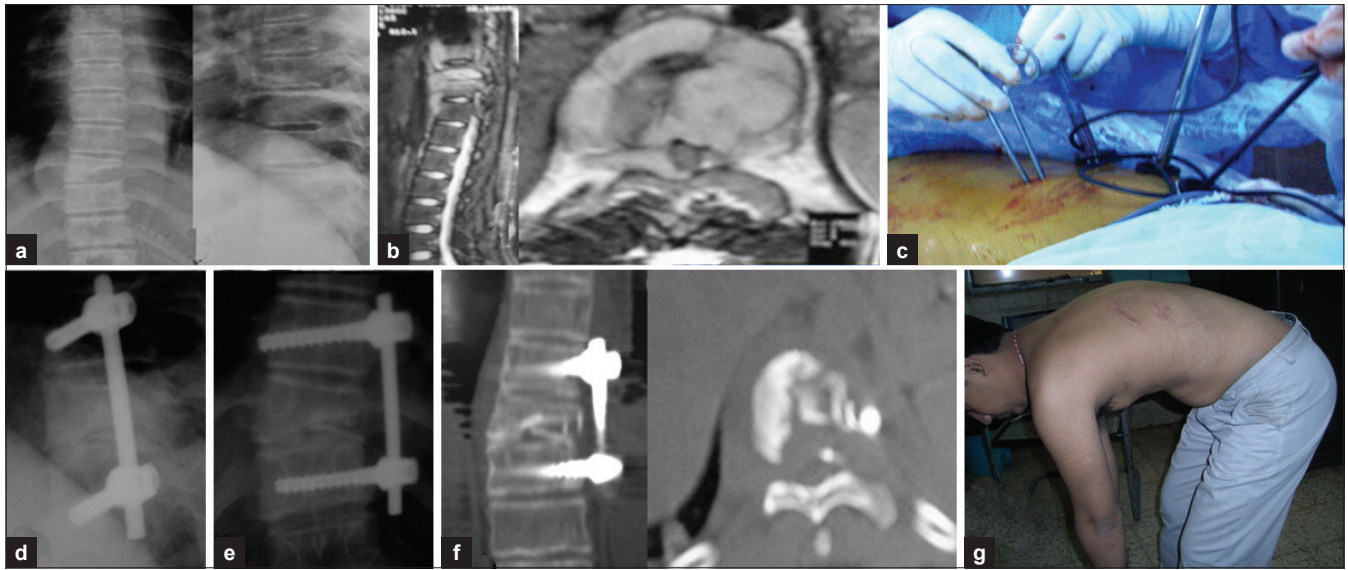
A 22 year old male with Potts paraplegia (Frankle B) at D9-10, Preoperative anteroposterior and lateral view of X-rays (a) showing decreased disc space between D9-D10 with partial destruction of D9. (b) Preoperative MRI saggital STIR image and T2 axial showing epidural, pre and para-spinal abcsess. (c) Peroperative description of thoracoscopic portals. (d, e) postoperative X-rays (anteroposterior and lateral) following video-assisted thoracoscopic decompression, anterior instrumentation, and bone grafting. (f) Postoperative CT scan saggital recon showing good fusion and axial image showing adequate decompression. (g) Clinical/neurological improvement to Frankel E
